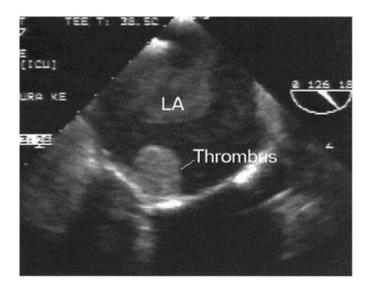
Thrombus seated on the mitral prosthetic valve ring demonstrated by transesophageal echocardiography. Significant spontaneous echocardiographic contrast is seen in the left atrium (LA).
